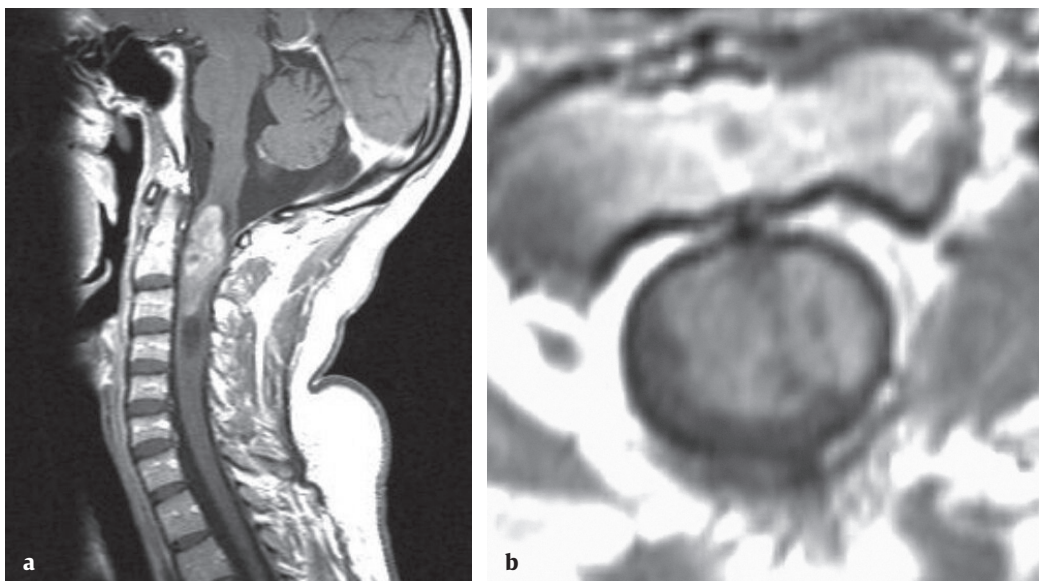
MRI of an intramedullary tumor (ependymoma), causing severe cord compression and myelopathy.
